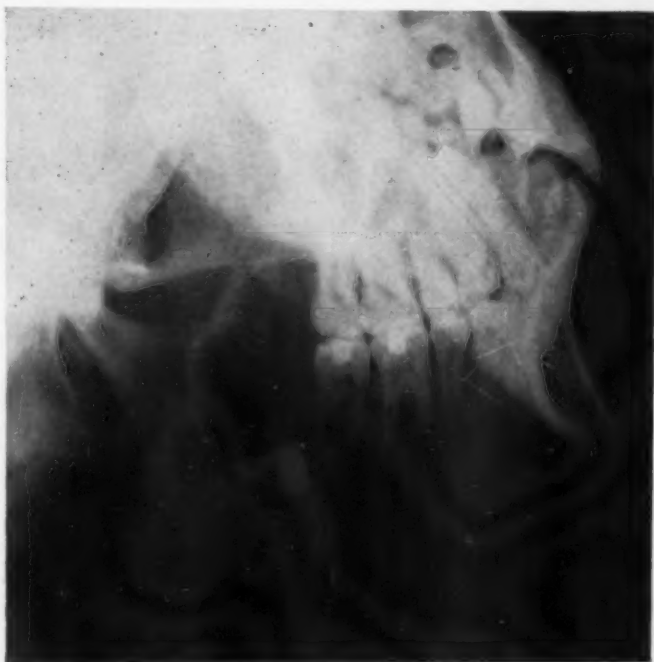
Case 4. Radiograph of an ameloblastoma in a seemingly dentigerous cyst. (Neg. 77905.)
